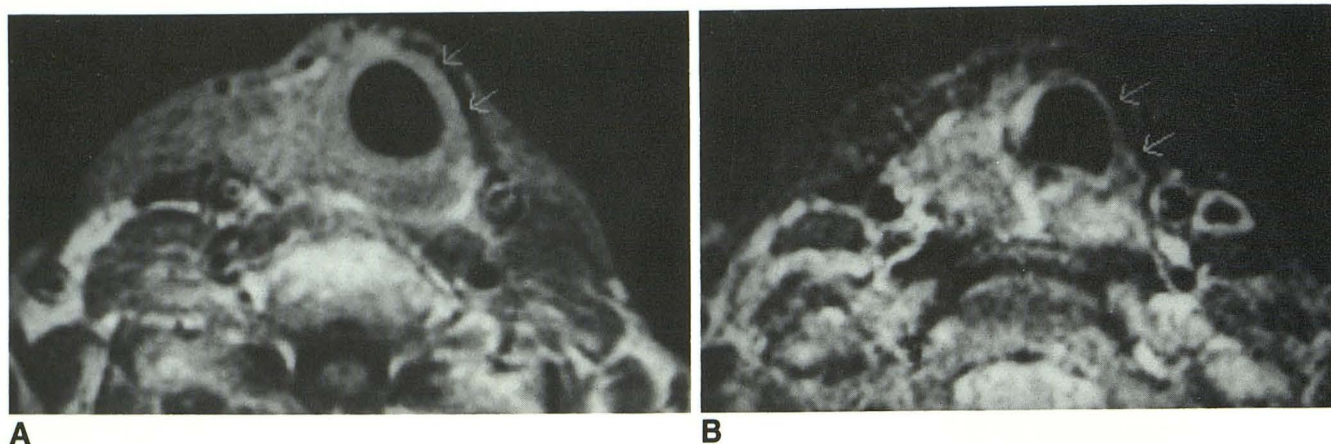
Spin-echo 500/20 (A) and 2000/80 (B) MR images of scarring in the left thyroid bed (arrow) after left thyroidectomy for papillary thyroid carcinoma. Fibrous tissue shows low intensity on both T1- and T2-weighted images.
